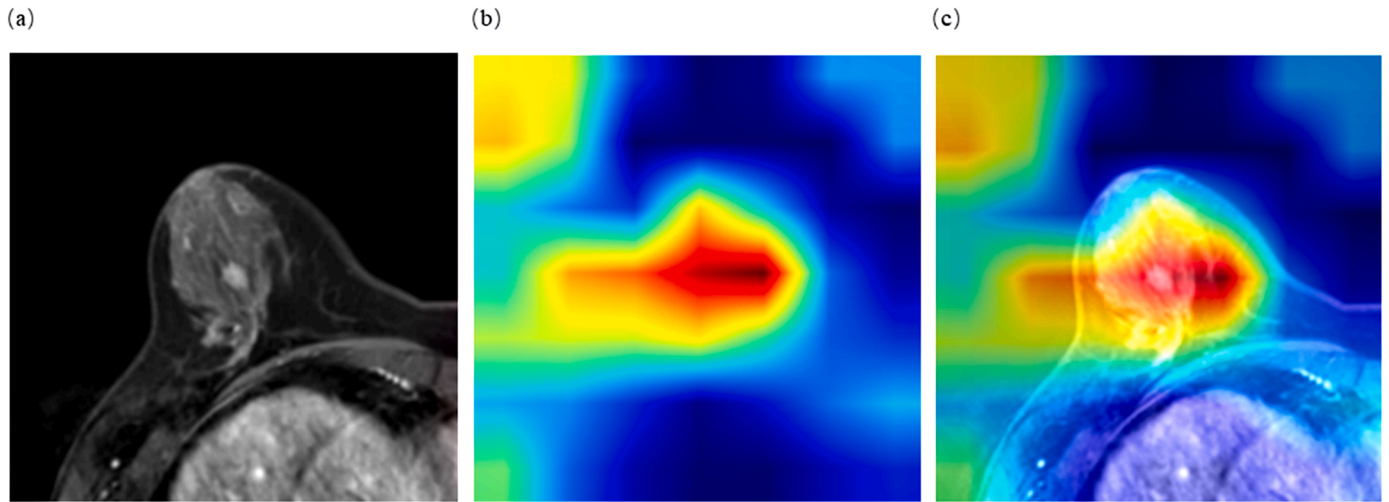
Class activation map of a patient with fibroadenoma in DCE-MRI of the Breast.
